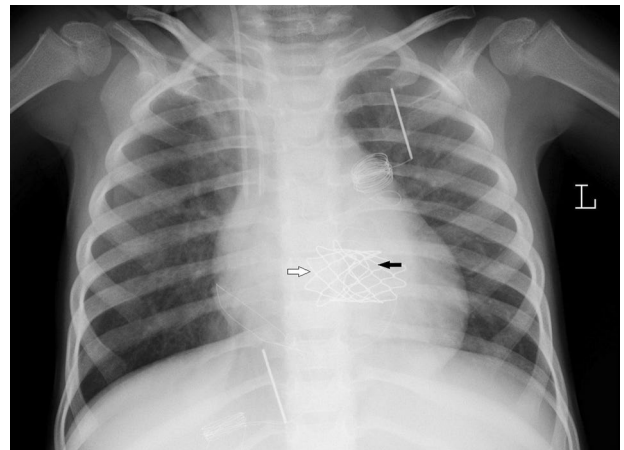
During the dilation, the balloon was maintained at 4 atm pressure, while all three circumferential semi-continuous sutures were tightened and tied. The position of the Melody valve was confirmed in postoperative chest X-ray: note flaring of the stent in the atrial part (white arrow) with resected distal segment (black arrow) to prevent left ventricular outflow tract obstruction
